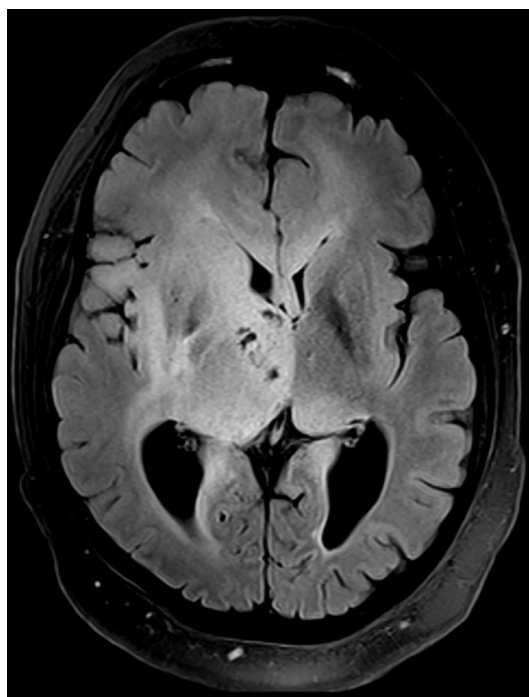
Diffuse infiltrative astrocytoma in a 21-year-old man with NF1. Axial fluid-attenuated inversion recovery (FLAIR) image shows a diffuse infiltrative tumor involving the right basal ganglia, right thalamus, left thalamic pulvinar, right insular cortex, corpus callosum, and periventricular white matter.
